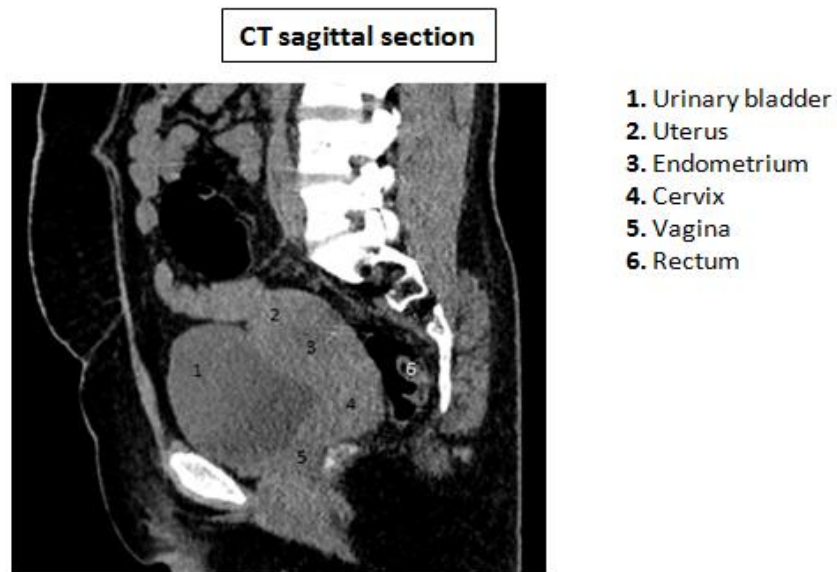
CT sagittal section of normal female pelvis
